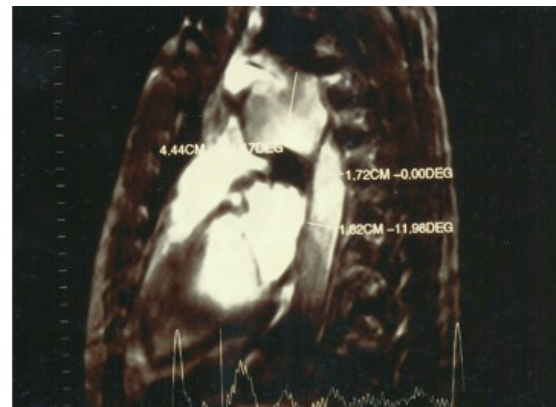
Angio MRI: Evidence of the relationship between the vascular intimal rupture post-traumatic descending thoracic aorta and the pseudo-aneurysm formation.
